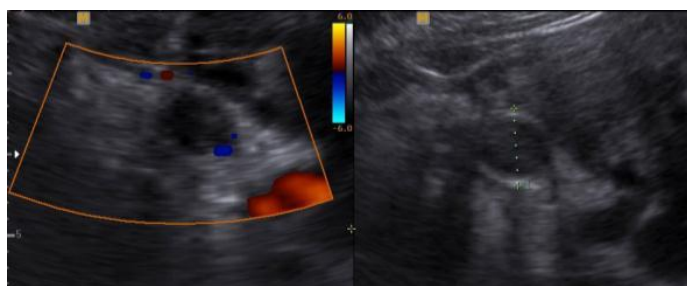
Doppler showing absent signals of appendix >1cm diameter Fig 7: Gangrenous appendicitis intra op
